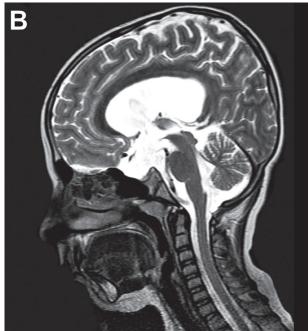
T2W-sagittal MRI of a 12-month-old boy included in this study. (A) Preoperative MRI showing a suprasellar arachnoid cyst extending to the third ventricle and the foramen of Monro, which caused the dilation of the lateral ventricles. (B) Reduction in the sizes of the cyst and the third ventricle after VC+ETV treatment in the postoperative first-month MRI. In addition, the CSF flow artifacts were observed at the site of VC (from the foramen of Monroe to the third ventricle) and ETV (from the third ventricle to the prepontine cistern).
